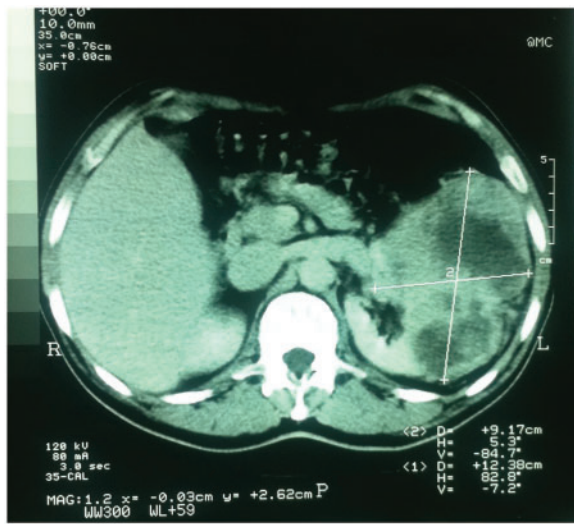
Abdominal CT scan shows a large hypo-dense mass with central necrosis arising from the lower pole of the left kidney.
